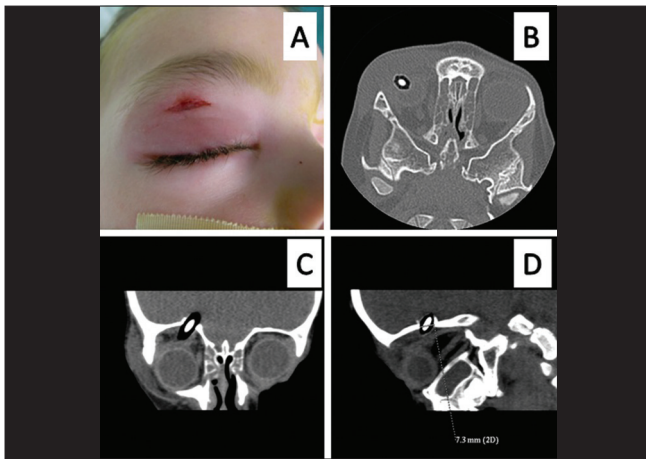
A Clinical photograph of the patient showing the eyelid laceration on the right central upper eyelid measuring 1.5 cm x 0.5 cm. B, C, D Computed tomography (axial, coronal and sagittal) of the brain and orbit showing a linear hyperdense foreign body with hypodensity all around it, measuring 4.2 cm x 0.8 cm in the right orbit, piercing the orbital roof and the dura, and entering the right frontal lobe. These features were suggestive of a broken pencil, the hyperdensity was due to the central core of the pencil made of lead and the hypodensity surrounding it was due to the wood
